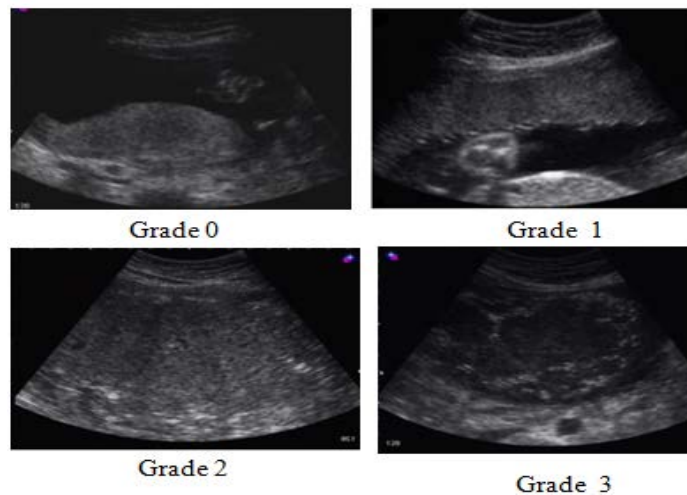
Sample images of placental sonograms
